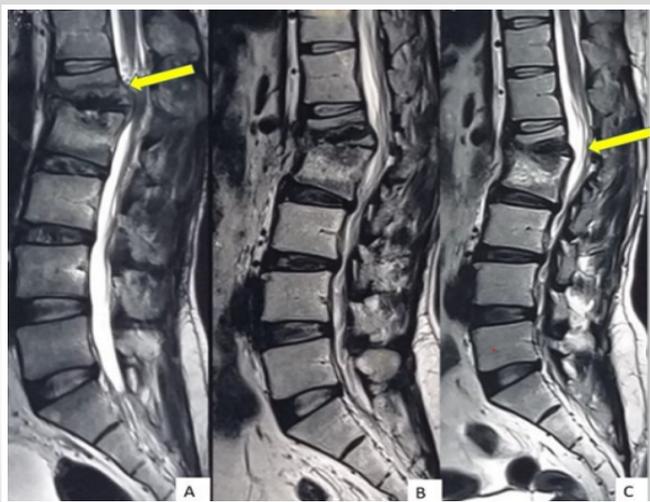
A 35 years old male patient presented with mild neurological deficits and Frankel D neurology. Patient was diagnosed as L1-2 tubercular discitis and Started on ATT. Patient underwent MRI at 6monthly intervals which are shown in the figure
